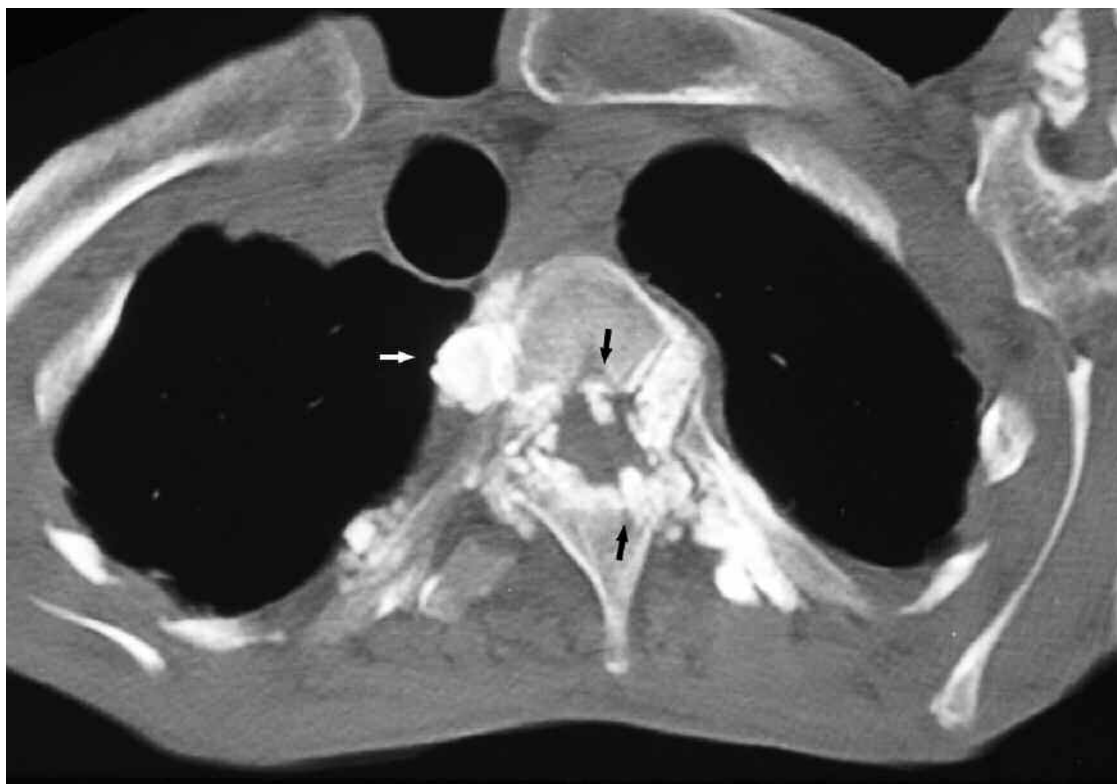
Computed tomography of the thoracic spine shows paraspinal calcinosis, concentrated in the intervertebral spaces (white arrow) at the Th4-Th5 level. Tumoral calcinosis is evident at the facet joints, causing significant narrowing of the spinal canal in conjunction with disc bulging (black arrow). Intraspinal calcinosis was not evident at the cervical and lumbar spine levels.
